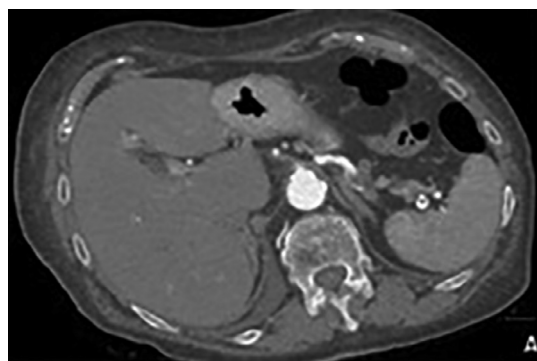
CT scan demonstrates splenic artery thrombosis and infarction of the spleen.
